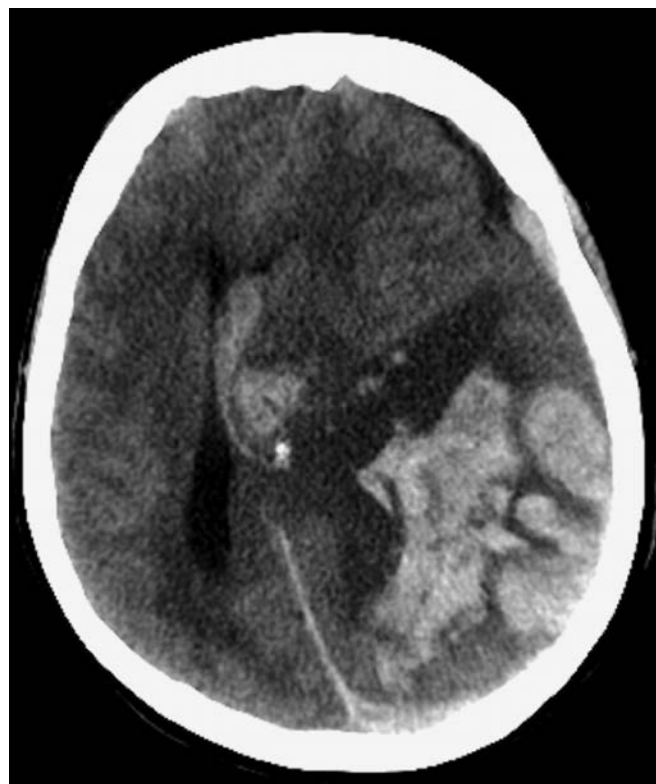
Intracerebral hypertensive hemorrhage. Noncontrast head CT scan with acute intraparenchymal hemorrhage, mass effect, midline shift, and intraventricular extension. [Image used with permission of Todd Siegal, MD.]
